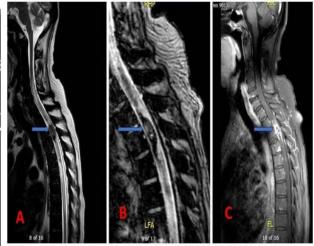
Sagittal T2 spinal MRI revealed long-segment intraparenchymal T2 hyperintensity seen extending from C6 to T4 vertebral levels suggestive of oedema (Fig 3A). Focal intraparenchymal haemorrhage is seen as hypo intensity on GRE images in spinal cord along T3 &T4 segments (Fig 3B).
